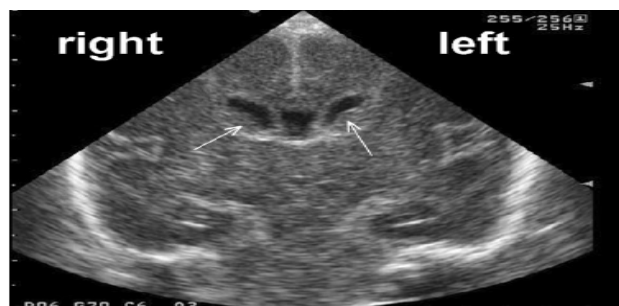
Coronal ultrasound scan in a very preterm infant at the level of the frontal horns of the lateral ventricles. If the marker on the transducer is positioned in the right corner of the anterior fontanel (see Figs. 2.1 and 3.1), the right side of the brain is projected on the left side of the image, and vice versa. Image shows germinal matrix haemorrhages of older duration (arrows)
